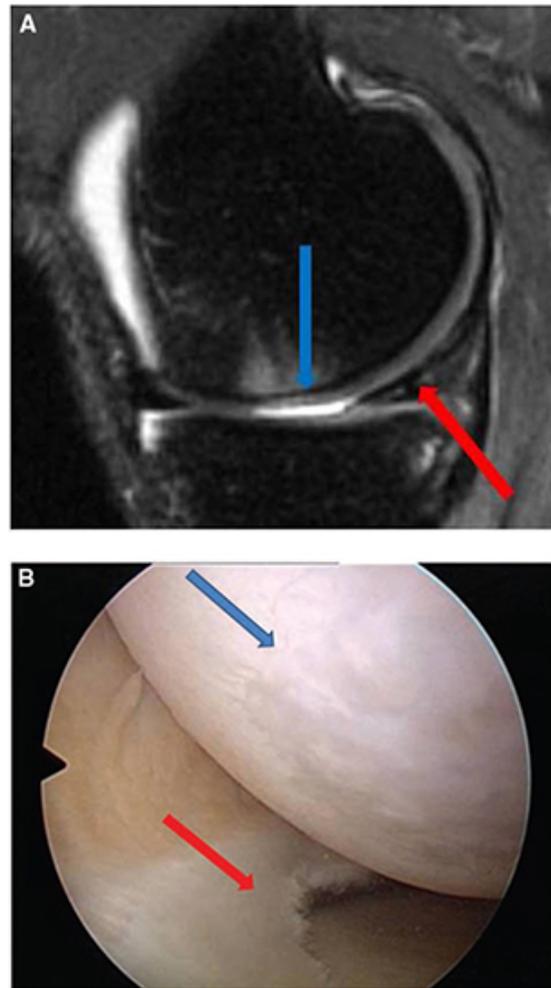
A, Sagittal magnetic resonance image of the NeoCart implant (gray arrow) at 12 weeks with adjacent posterior horn meniscal tear (white arrow). B, Arthroscopic image of the NeoCart implant in situ after arthroscopic meniscus debridement. The NeoCart (blue arrow) appears flush and integrated to the area of medial meniscectomy (red arrow).
